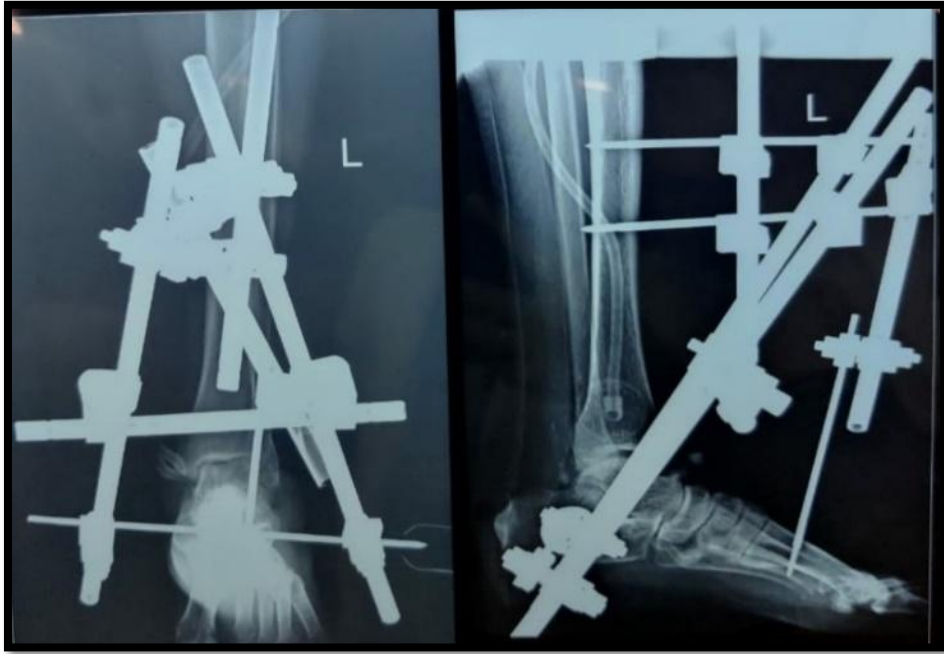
Post-operative X-Ray of Delta fixator on Ankle joint
